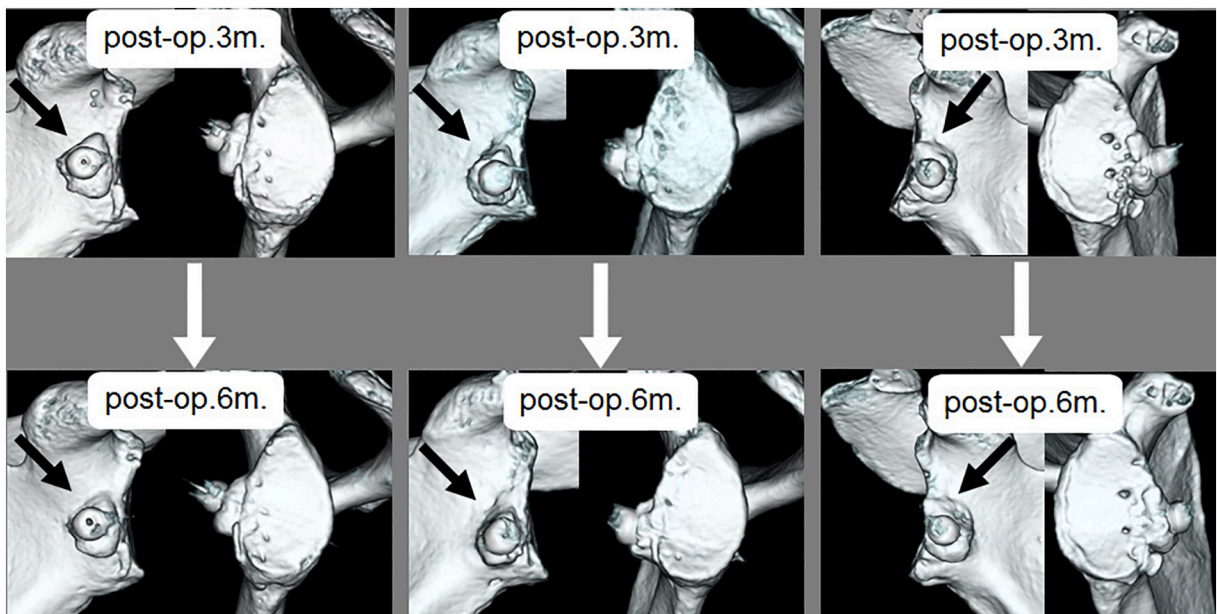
3D-CT images at 3 and 6 months: 9 shoulders showed the slight bone resorption at the proximal end of the graft at 6 months.
